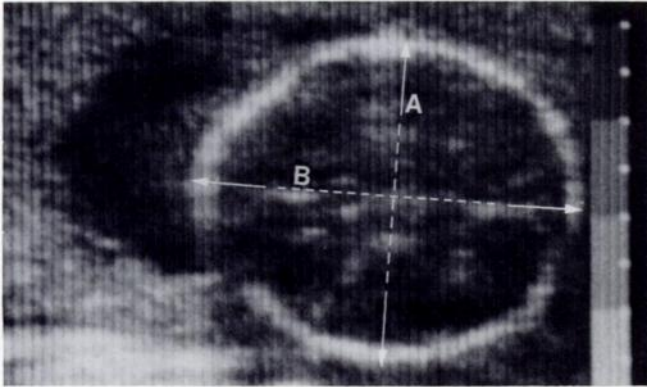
Real-time sonographic image of fetal skull at level of biparietal diameter. Cephalic index is $A/B \times 100$.
